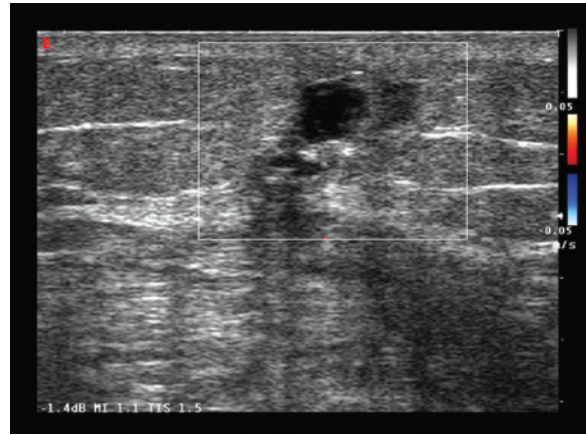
b Lipoma-like liposarcoma of the arm. Relatively well-defined and homogeneous hypoechoic mass at US (a), with a homogeneously hyperintense appearance on the axial MR image (b)
